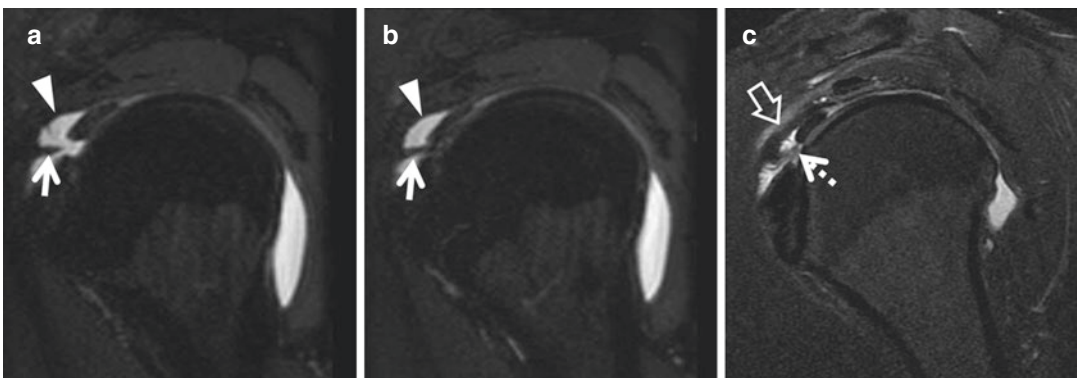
Normal and abnormal biceps pulleys. (a and b) Reformatted sagittal-oblique MR arthrogram image from a T1-weighted fat-suppressed 3D-FSE acquisition shows a normal biceps pulley, including a normal superior glenohumeral ligament (white arrows) and coracohumeral ligament (arrowheads). (c) Sagittal-oblique T2-weighted
